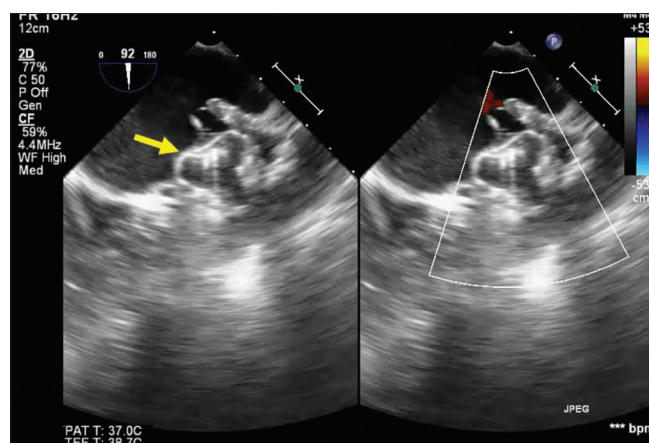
A Watchman® left atrial appendage occlusion device in place (arrow). The right-side image shows color Doppler evaluation to rule out any residual peri-device leak
